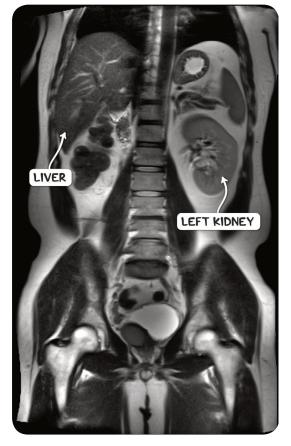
An MRI scan in the coronal plane demonstrating right-sided renal agenesis.
